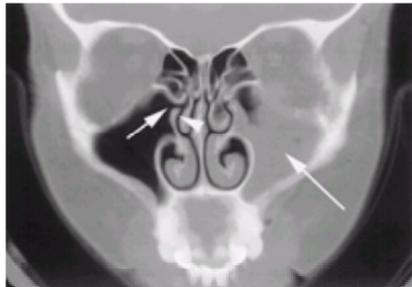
Chronic sinusitis. Coronal, nonenhanced screening sinus computed tomography through the face shows opacification of the left maxillary sinus caused by chronic inflammation (*long arrow*). The osteomeatal unit (*short arrow*) and uncinete process (*arrowhead*) are clearly demonstrated on the opposite side.
